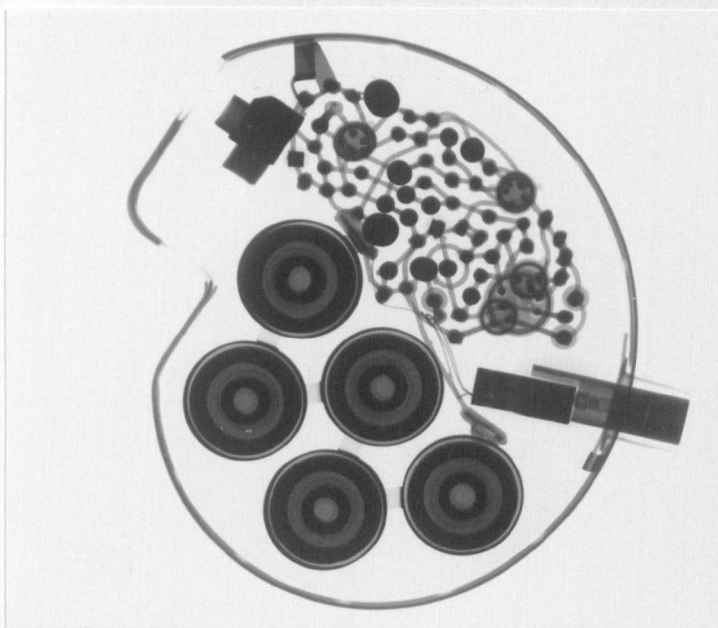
Radiograph showing break in one lead of bipolar myocardial electrode-lead system.
